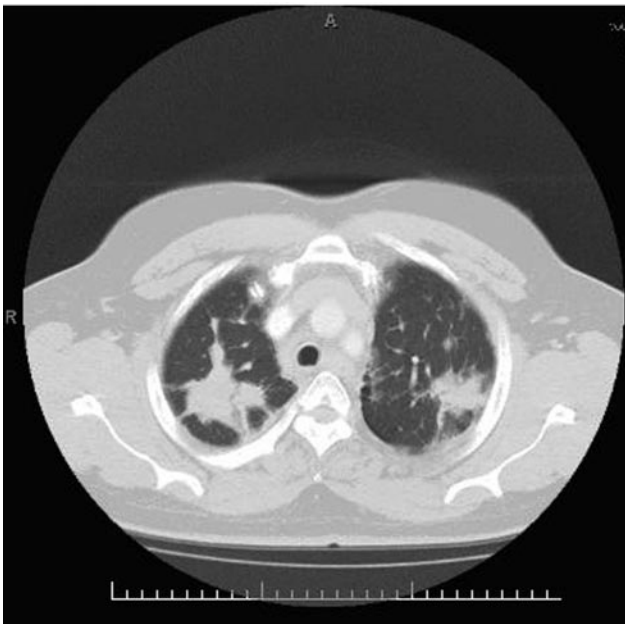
Computed tomogram shows conglomerate masses in the upper lobes, consistent with progressive massive fibrosis.
